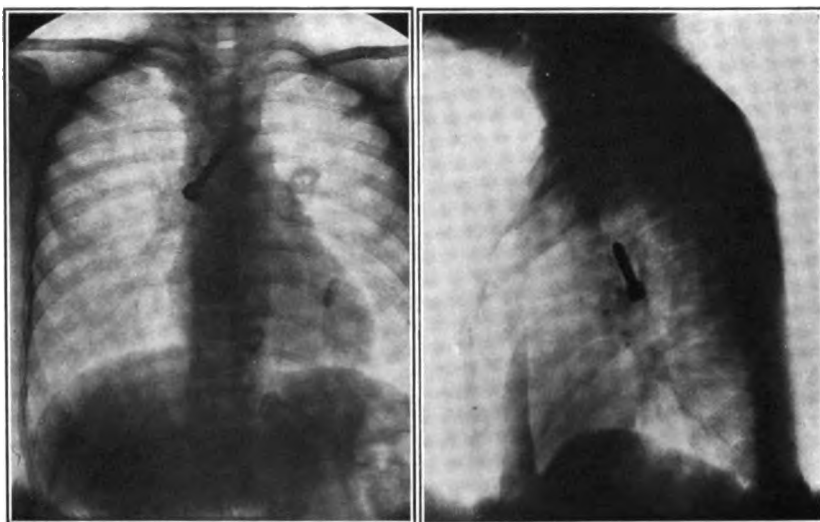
Roentgenogram showing an iron casting in the right bronchus of a child of 8 years. The movements of the casting are shown in Figure 3. Foreign body removed by peroral bronchoscopy without anesthesia.
